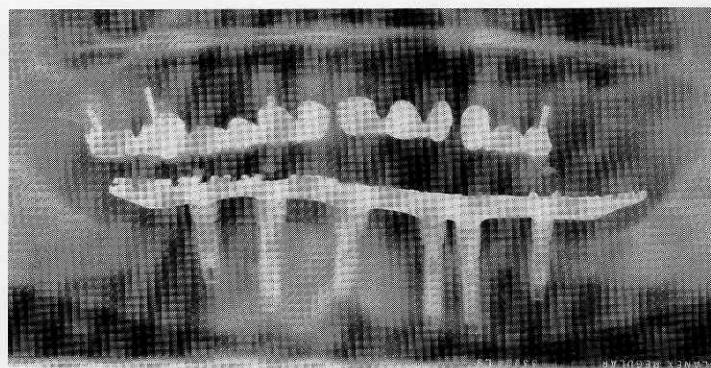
Immediate postoperative panoramic radiograph. Note osseous defect.
